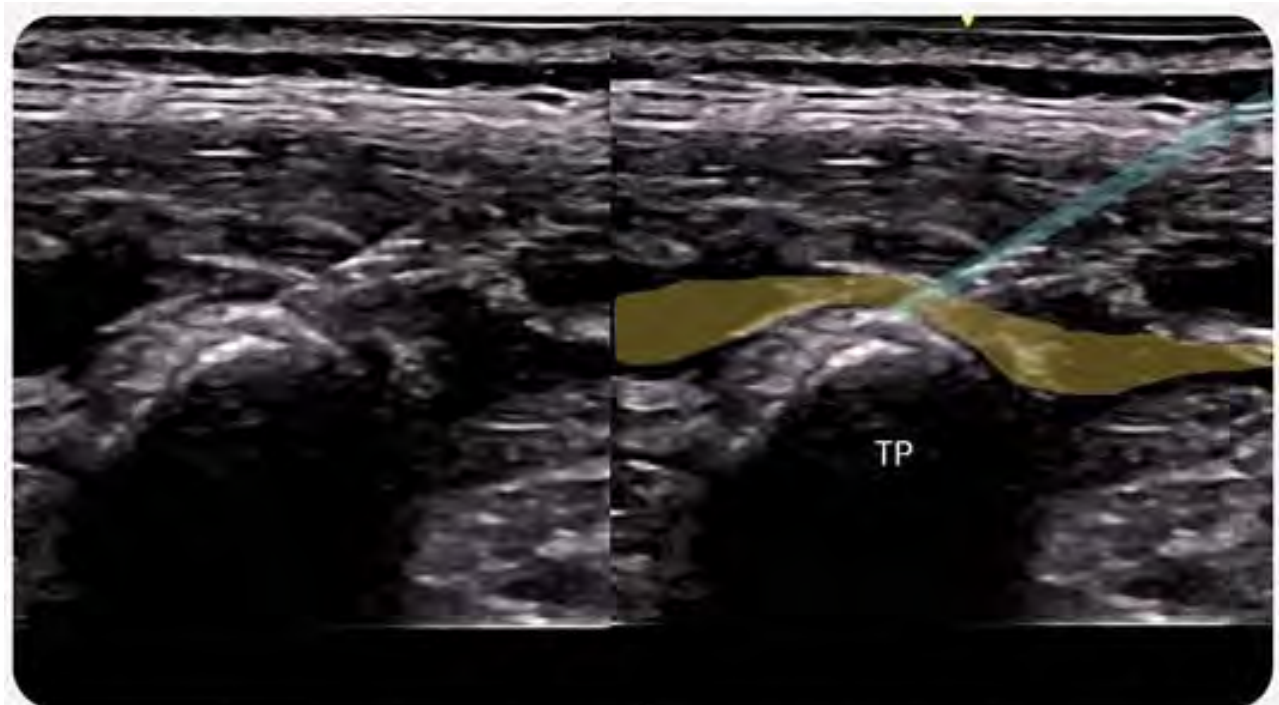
Ultrasound demonstrating needle to ESP at the level of T10 (cranial- caudal orientation)
